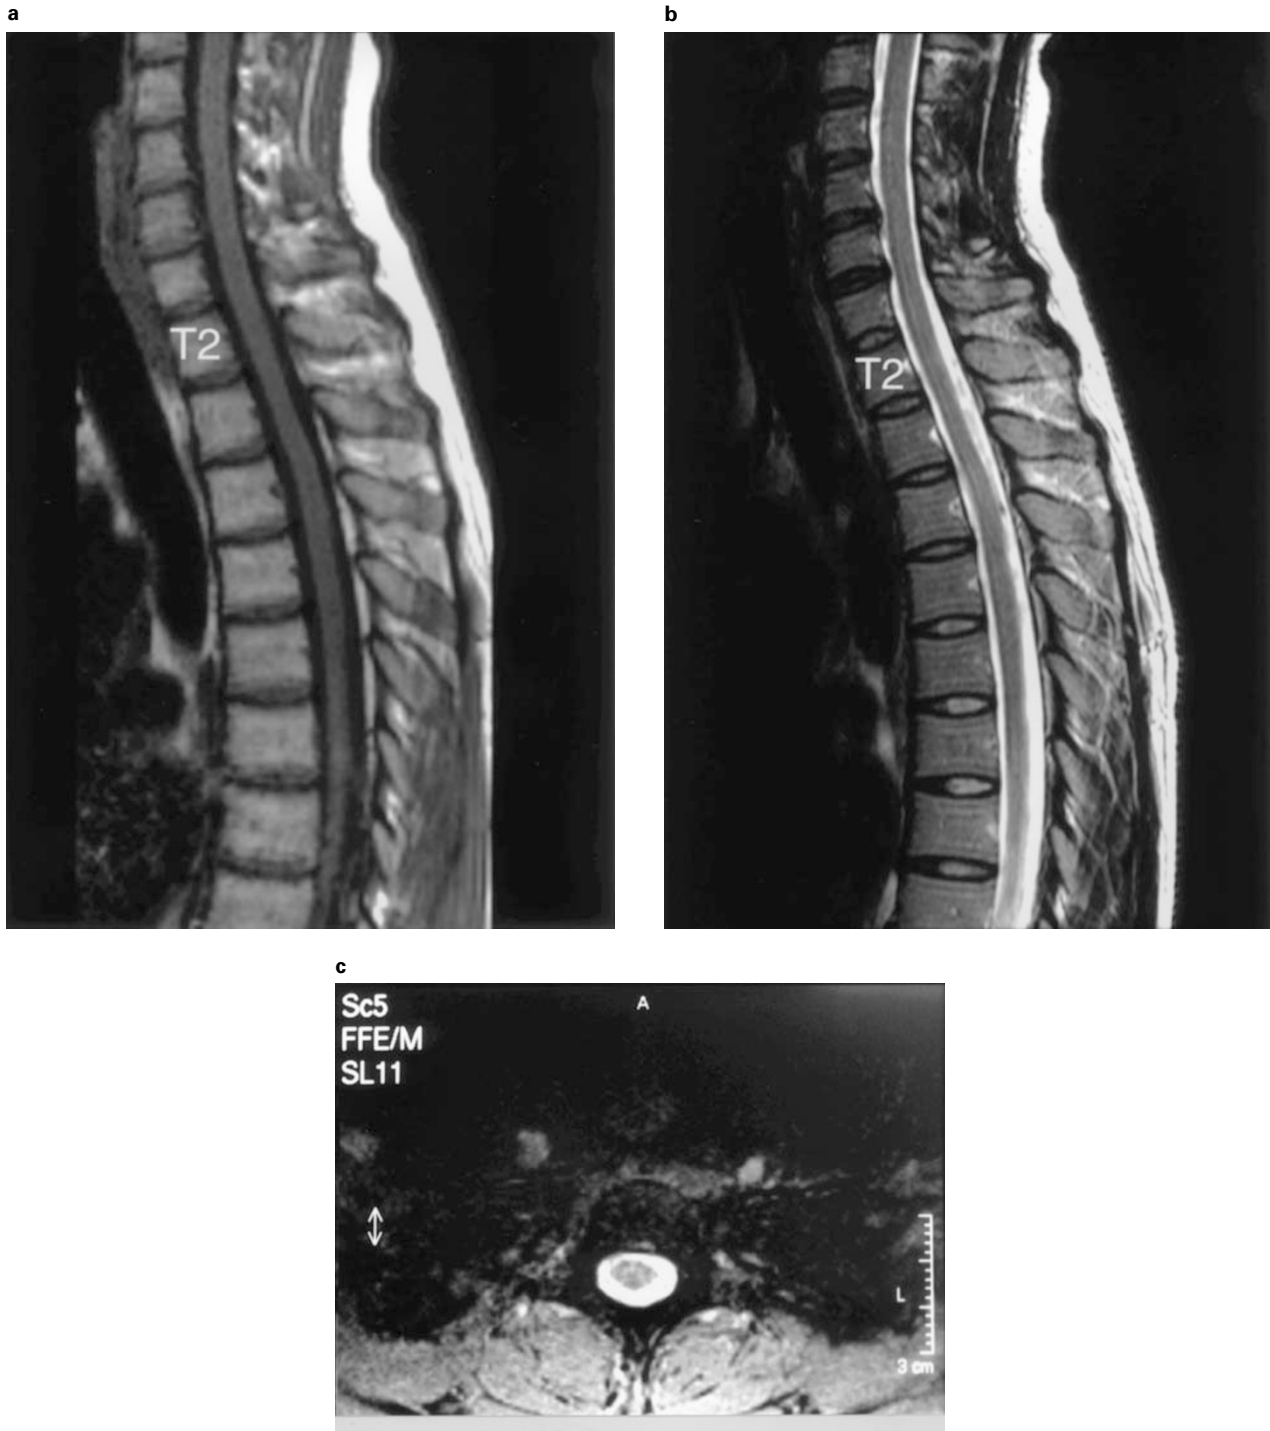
MRI 3 months after the onset, revealing a complete resolution of SSH. (a) T1W1, Sagittal plane. (b) T2W1, Sagittal plane. (c) T2W1, Axial plane
